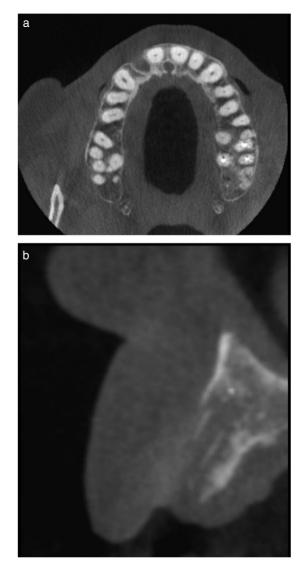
2a and 2b. Occlusal and sagittal view of CBCT scan exhibiting vertical and horizontal bone loss requiring three-dimensional bone augmentation to place implant in optimal position.
